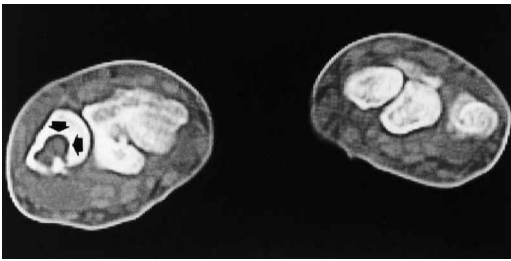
Case 2. CT scan showed a cyst-like erosion in the ulna, and synovial hypertrophy in the palmar aspect of the left wrist.
